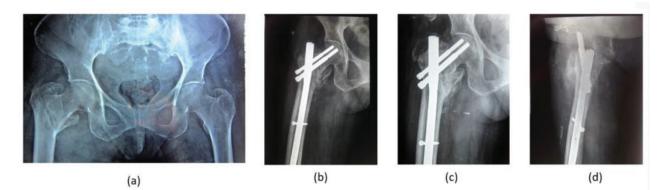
a: Radiograph of left hip showing AO31A3.1 fracture.
